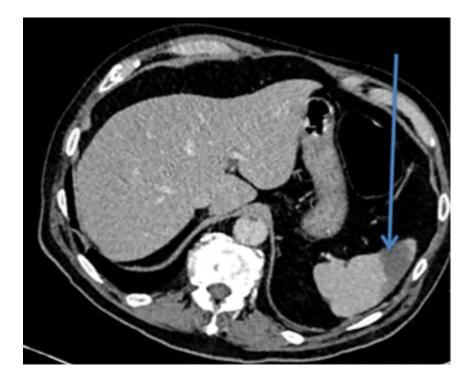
CT-arterial portography.
